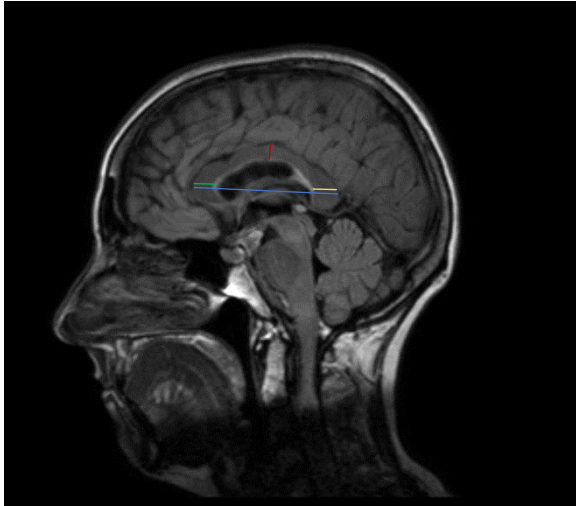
Sagittal FLAIR MRI scan.
